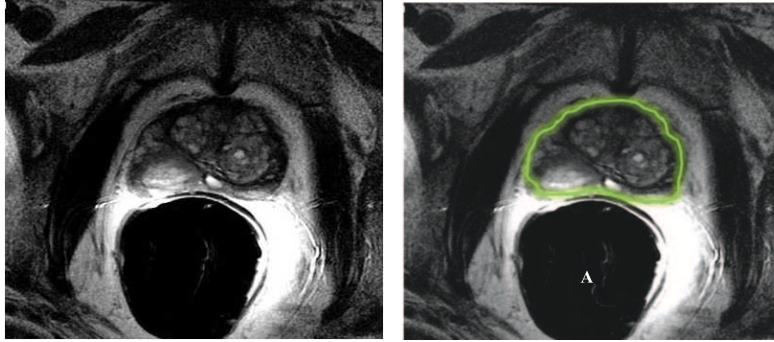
In MRI imaging, the better soft tissue contrast enables lesion detection. Image (a) shows a prostate in MRI. For a better understanding of the prostate region, the contour is outlined in green in (b).
